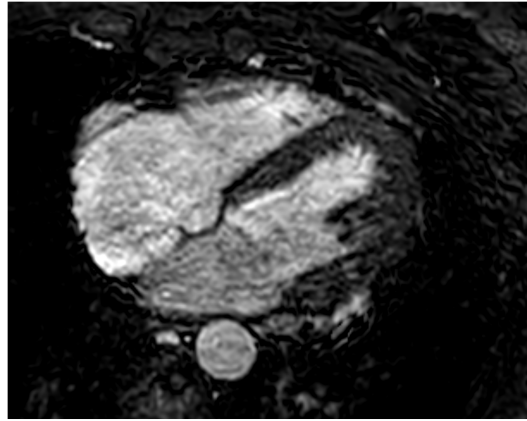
One MR image of the data set, in which the four chambers are visible.
